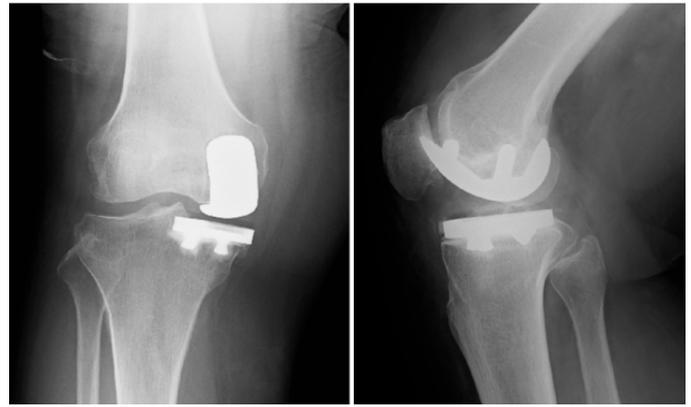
Postoperative anteroposterior and lateral radiographs of the patient showing medial unicompartmental arthroplasty.
